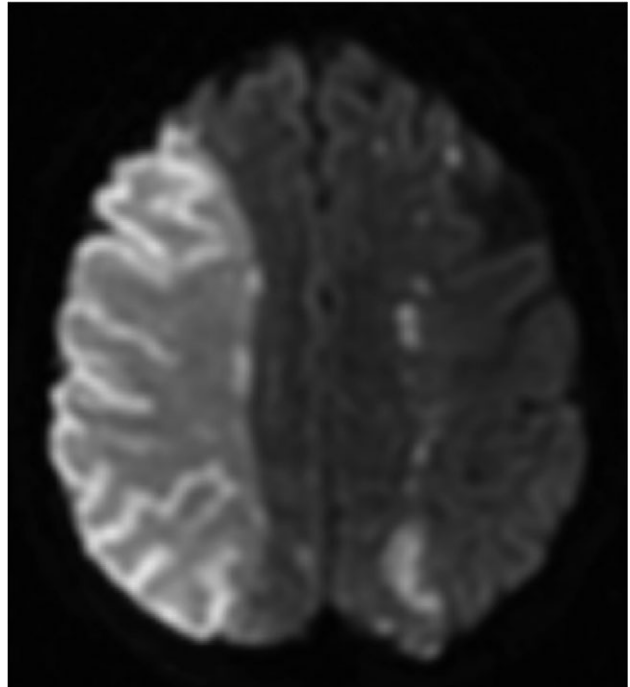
MRI of the brain. Diffusion-weighted imaging showing a right middle cerebral artery and left watershed infarct.
